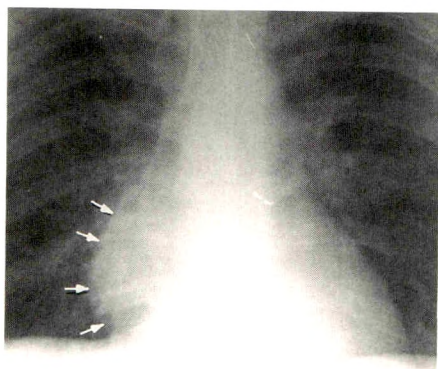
Posteroanterior chest radiograph shows enlargement and slight lobulation of right cardiac margin (arrows) due to large right anterior mediastinal thymoma.
